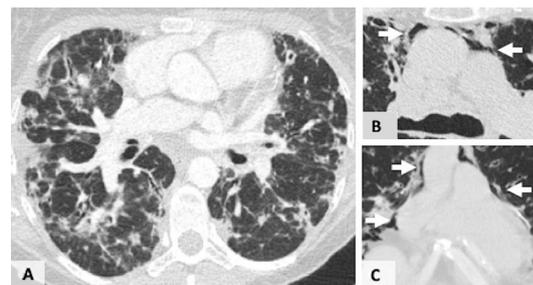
(A) Axial CT image of the chest in a patient with common variable immunodeficiency, showing interstitial fibrosis with subpleural and peribronchovascular consolidation consistent with granulomatous–lymphocytic interstitial lung disease, proven on lung biopsy. (B, C) Axial CT image and coronal reconstruction showing the small spontaneous pneumomediastinum (arrows) as a complication of recurrent infections and coughing in the same patient.
